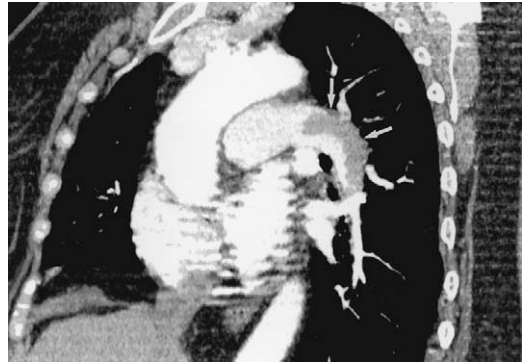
Sagittal-oblique reformatted multislice CT image shows extent of thrombus narrowing the left lower lobe pulmonary artery as it curves posterolaterally and inferiorly (arrow).
